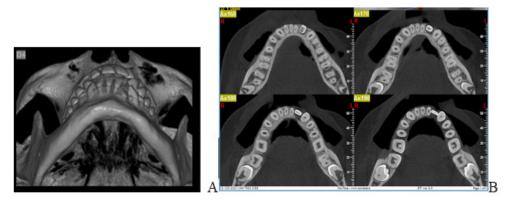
A: Submental view: asymmetric mandibular border. B: Axial section of mandibular cone beam computed tomography image.
